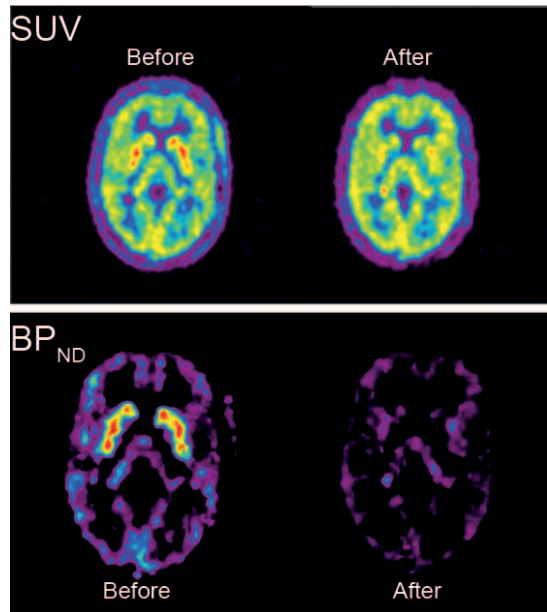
Two sets of images from the same 90 minutes [^{11}C]R116301 scans of a healthy subject before (left column) and after (right column) a 125 mg oral dose of aprepitant. SUV images (top row), based on a static portion (60 – 90 minutes after tracer injection) of the 90 minutes scan, show a significant contribution from nonspecific binding. Parametric binding potential (BP_{ND}) images (bottom row) based on kinetic analysis of the entire dynamic 90 minutes scan show nearly complete blocking (97%) by aprepitant. (adapted from Lammertsma et al. Forward to the Past: The Case for Quantitative PET Imaging, J Nucl Med. 2017; 58:1019-1024 © SNMMI³¹)
